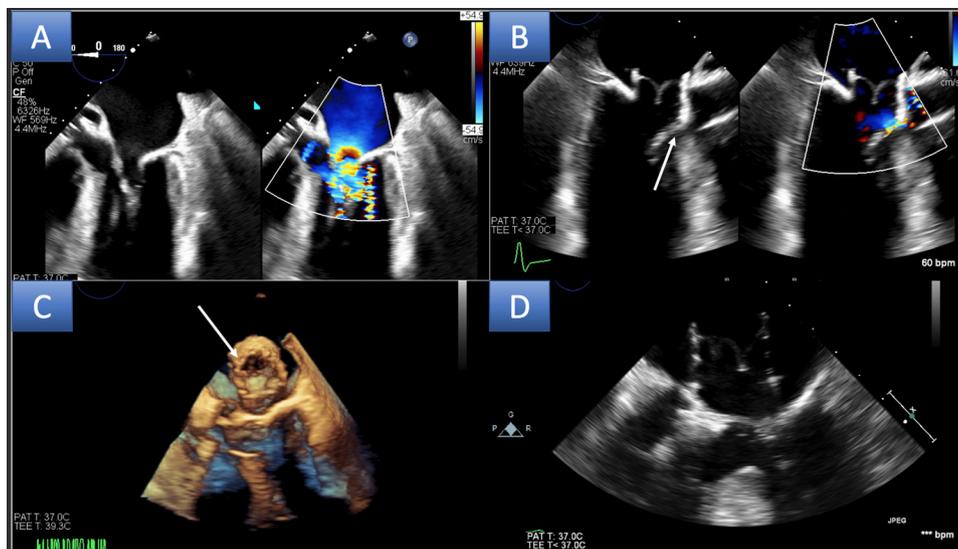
Displays transesophageal echocardiographic images pre- and post-procedure. (A) Midesophageal 4 chamber 2-dimensional (2D) and color compare images pre-procedure. (B) Midesophageal long-axis 2D and color compare, (Note-arrow demonstrates Edwards Sapien prosthetic in contact with the interventricular septum). (C) Three-dimensional echocardiographic image displaying the embolized TMVR valve into the left atrium. (D) Midesophageal long-axis 2D echo image displaying the embolized prosthetic valve into the left atrium.
